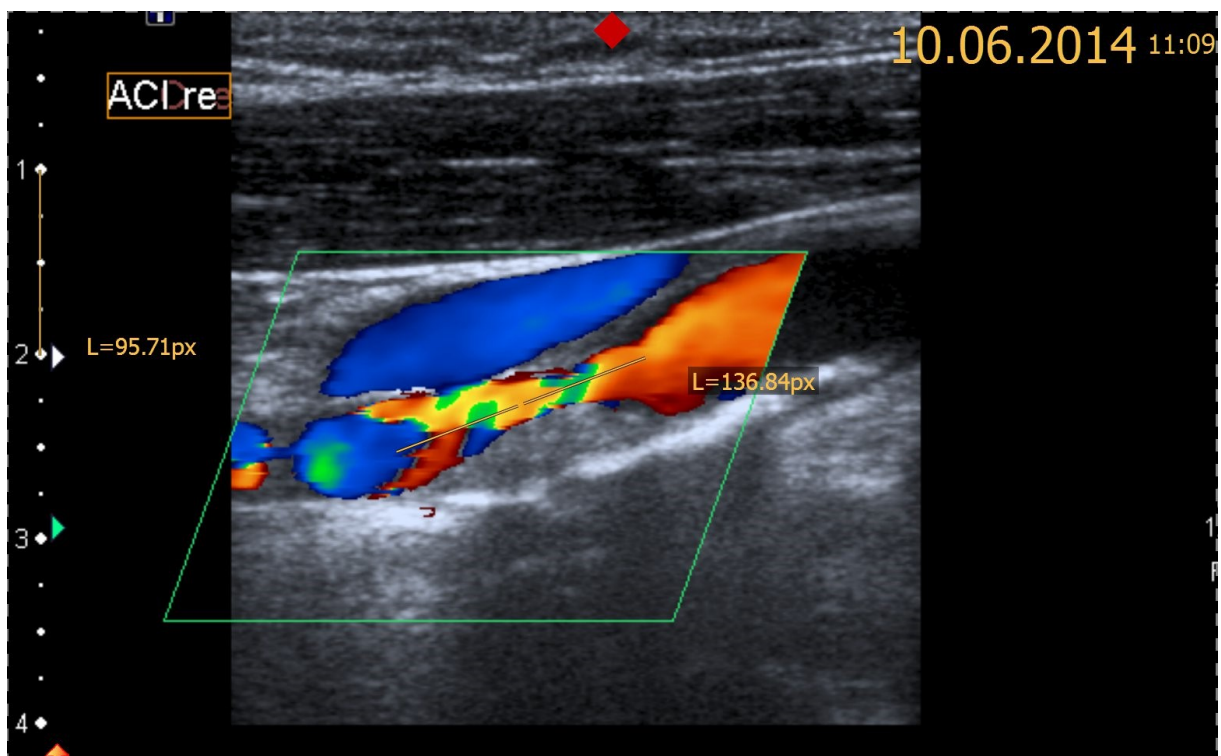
Ultrasound examination (patient 77) showing a large plaque causing an ICAD of 70%, with a length of 14 mm on the right side
